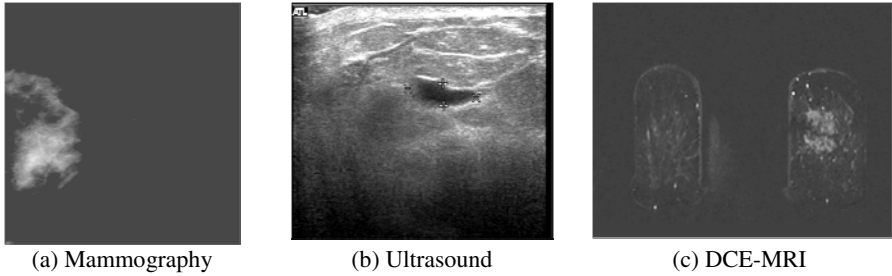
Example lesion in triple-modality database: (a) mammography, (b) ultrasound, and (c) DCE-MRI images of the same lesion
